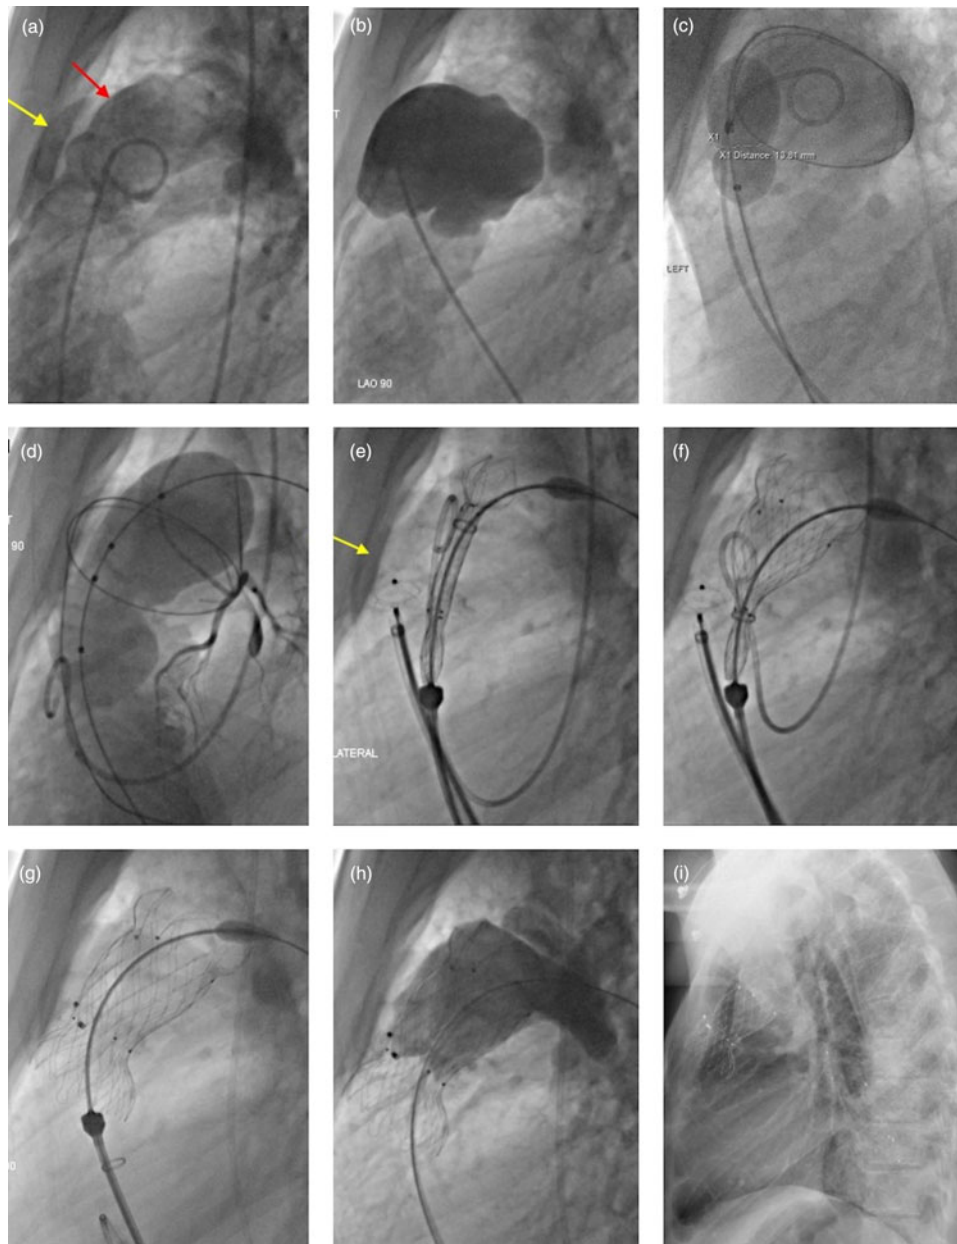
Procedure shown in left lateral projection. (a) Right ventricular outflow tract (red arrow); adjacent right ventricular outflow tract aneurysm (yellow arrow); (b) right ventricular outflow tract aneurysm angiogram; (c) balloon sizing across the mouth of right ventricular outflow tract aneurysm over coiled guidewire; (d) balloon sizing across the right ventricular outflow tract with simultaneous angiogram and left main coronary angiogram; (e) valve assembly of the right ventricular outflow tract – with partially deployed distal flare. Amplatzer device deployed (yellow arrow) in the mouth of aneurysm. (f) Deployment of middle portion of the valve. Note: Amplatzer device still not released. (g) Complete deployment of the valve after the release of Amplatzer device. (h) Pulmonary angiogram demonstrating well-positioned and well-functioning Venus P-valve with Amplatzer device in position across the right ventricular outflow tract aneurysm. (i) Lateral chest X-ray at discharge showing Venus P-valve and device in position.
